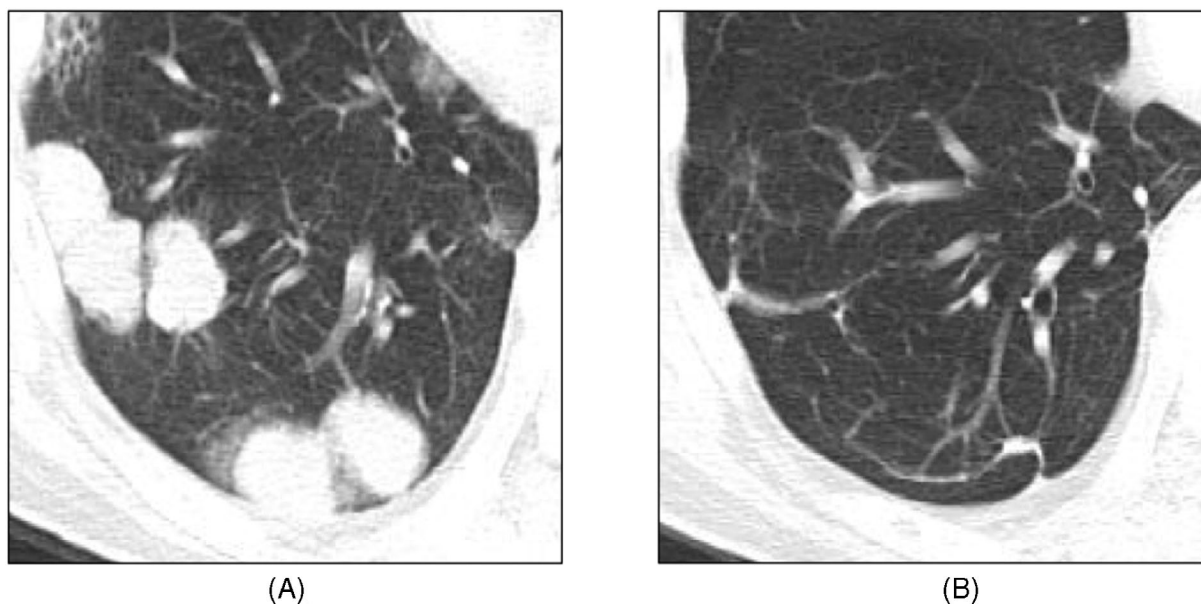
Computed tomography (CT) showing tumor disappearance of a right lung metastasis in a patient with salivary duct carcinoma (case 10: A, B). (A) Plain CT of a right lung metastasis before starting pembrolizumab. (B) Plain CT of the same lesion after administrating 17 cycles of pembrolizumab
